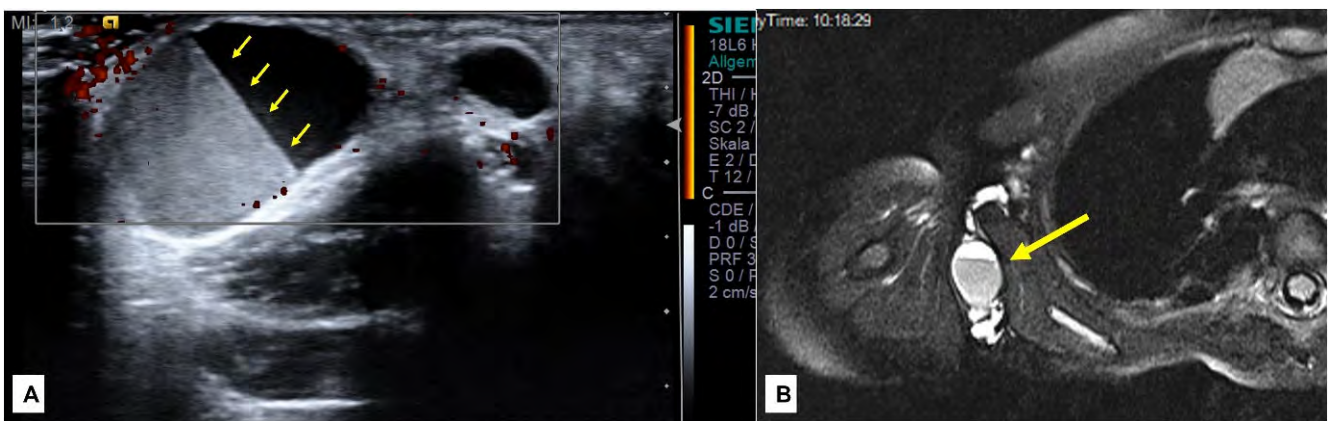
A 2.5-year-old girl with a sudden appearance of a lump in the right axilla. Ultrasound examination showed a multi-cystic mass with intracystic bleeding documented by the fluid-fluid level in the cyst representing the clot retraction (A)—(yellow arrows). The MRI (B) showed the exact extension of the mass (arrow), which was limited to the subcutaneous tissue and facilitated the indication for surgical resection.
